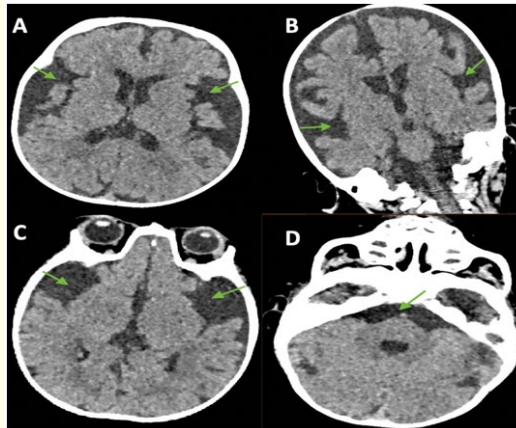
Axial and coronal CT scan sections showing enlargement of lobe frontotemporal fluid spaces and sylvian valleys “Bat wing appearance” (A, B) enlarged CSF spaces anterior to the temporal (C), enlarged prepontine cistern.
